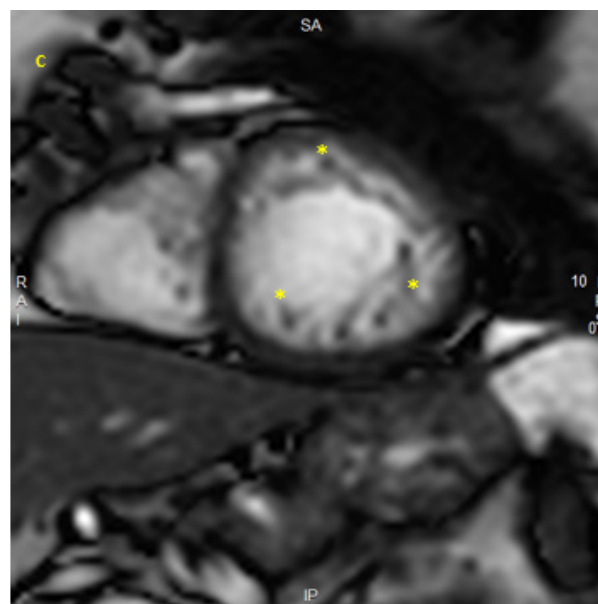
MRI apical short axis image at end-diastole 2024 showing the unchanged trabeculation (asterisk) and improvement of systolic function.
